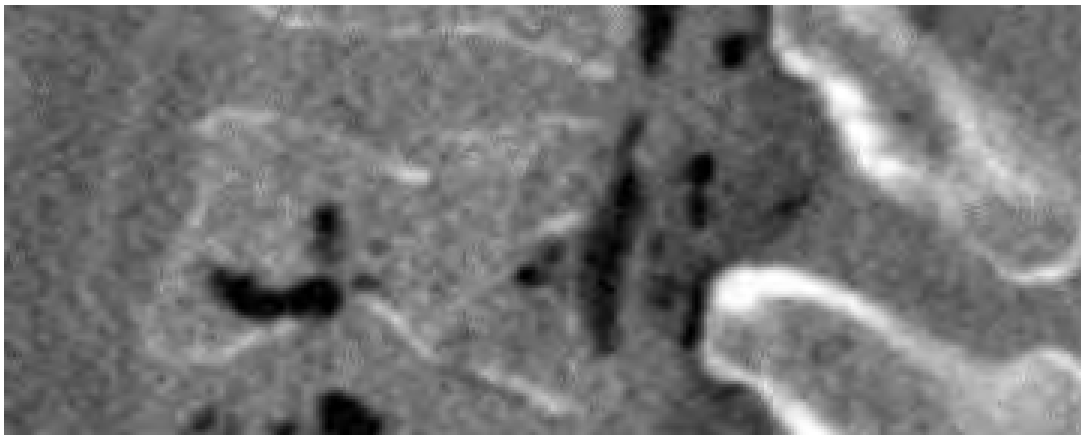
Figure E-1. CT image of compression fracture of L3 of MS1C1 (left lateral view)
